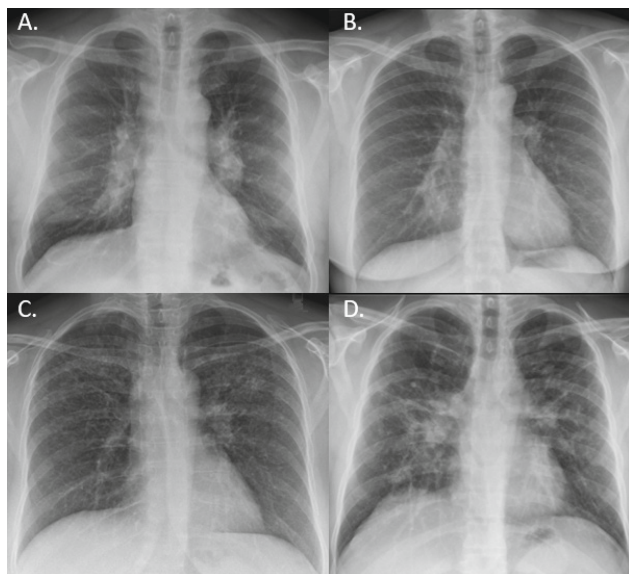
Example of chest radiographs of a patient with A. Scadding stage I with bilateral hilar lymphadenopathy, B. Scadding stage II with bilateral hilar lymphadenopathy and parenchymal infiltrates, C. Scadding stage III with parenchymal infiltrates and D. Scadding stage IV with fibrosis.
